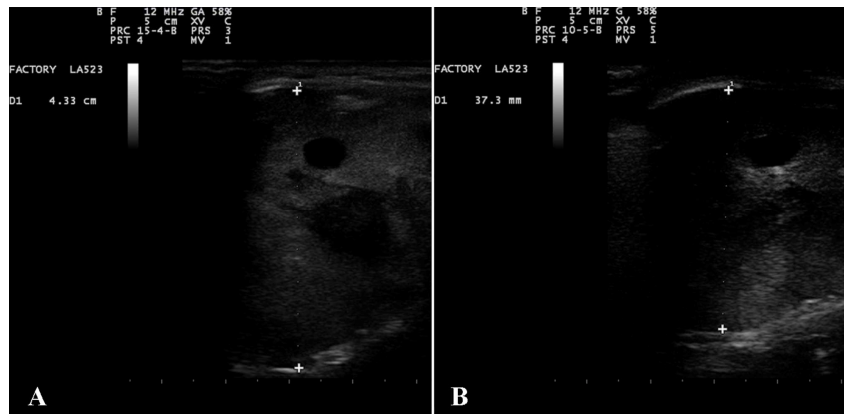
Ultrasonography of bone metastasis. A 60-year-old man was diagnosed with metastatic thyroid cancer to bone and soft tissue. After 4 weeks of integrative immunotherapy where OA-GcMAF (880 ng/day) was administered by alternating nebulisation and localised subcutaneous injections, one of the bone metastases taken as representative, measured with ultrasonography, showed a decrease of its thickness from 43.3 mm (panel A) to 37.3 mm (panel B). This corresponds to an approximate 14% linear diameter reduction. In this case the volume could not be fully extrapolated since the mass showed an irregular shape
